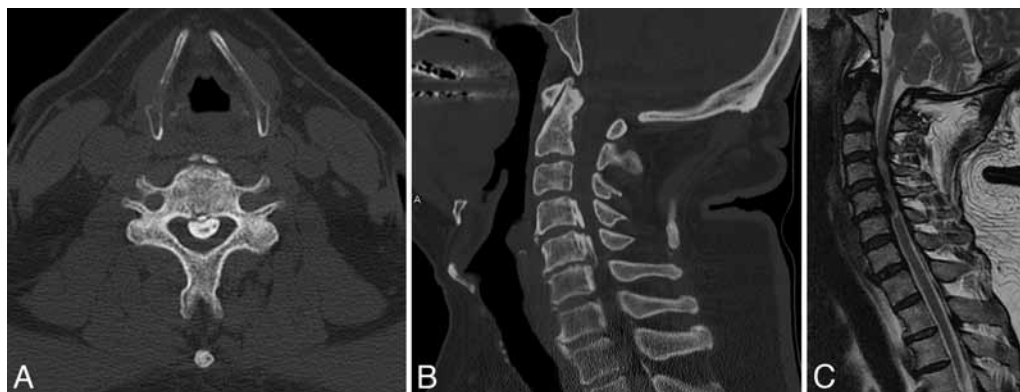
Representative images obtained in a 58-year-old man with cervical OPLL from C-4 to C-6. Axial CT scan (A) and sagittal CT reconstruction (B) demonstrating an OPLL mass. Sagittal T2-weighted MR image (C) showing high signal intensity in the medullary region from C-4 to C-6.
